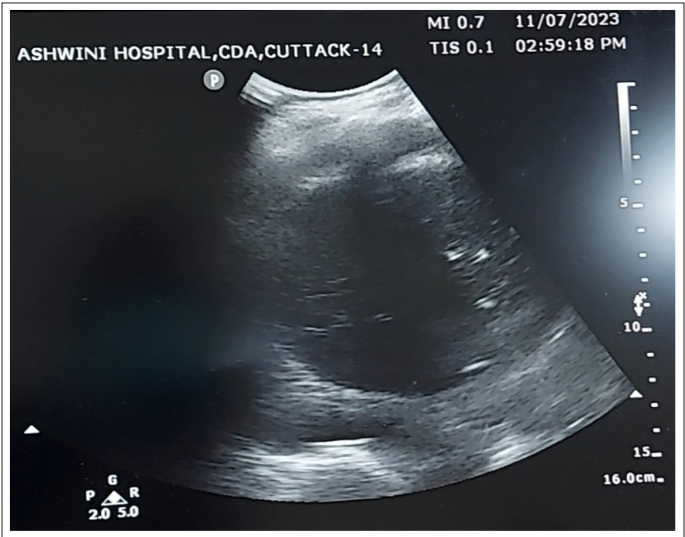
Echoic Ultrasonography Finding
